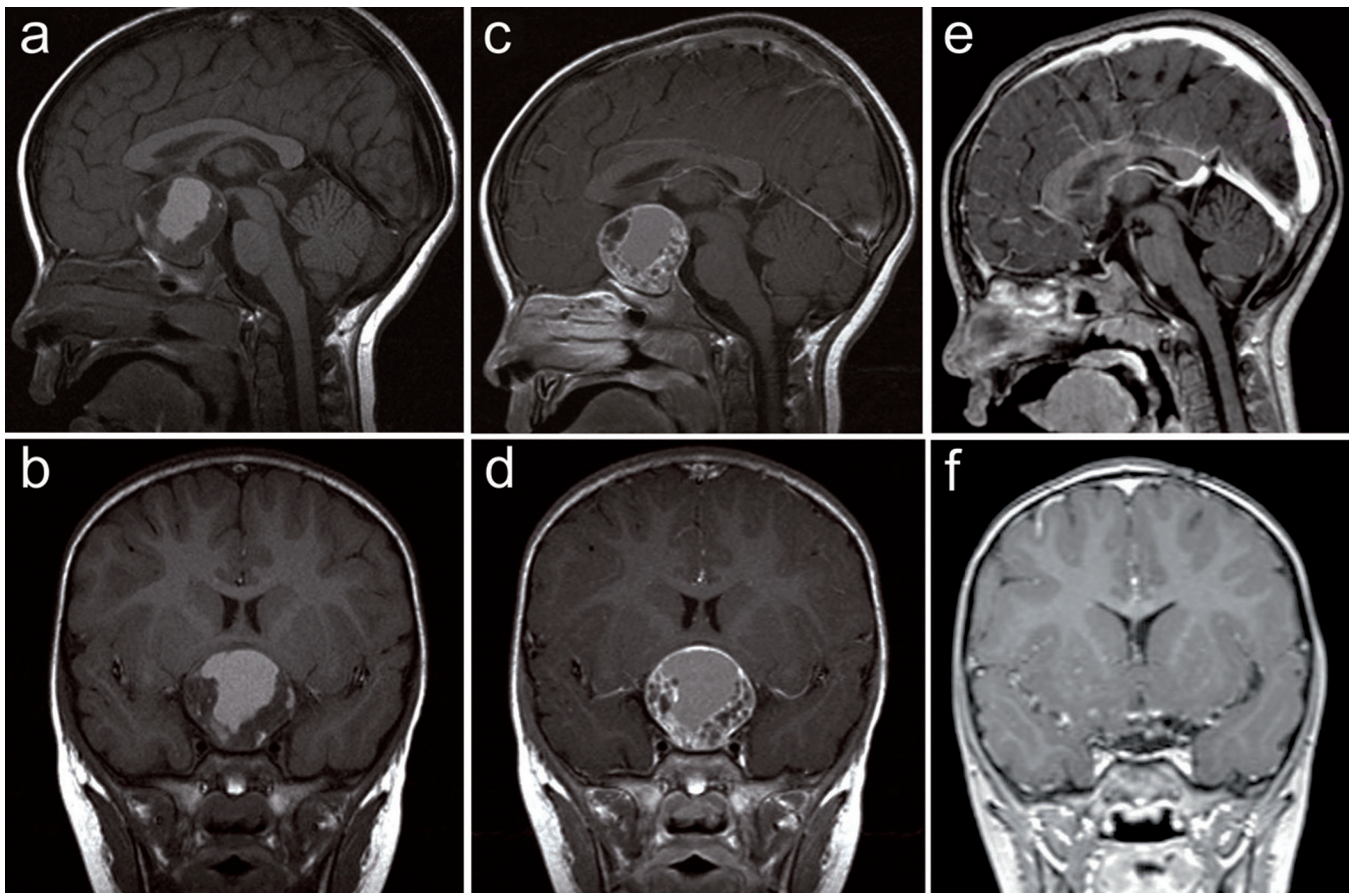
a-d: Preoperative T1-weighted sagittal and coronal MR images, without (a and b) and with (c and d) gadolinium, demonstrating the presence of an expansive sellar lesion of 3.8-cm maximum diameter, with considerable compression of the optic chiasm. e and f: Postoperative Gd-enhanced T1-weighted sagittal and coronal MR images obtained 1 year after surgery confirming complete removal of the tumor and absence of any recurrence.
